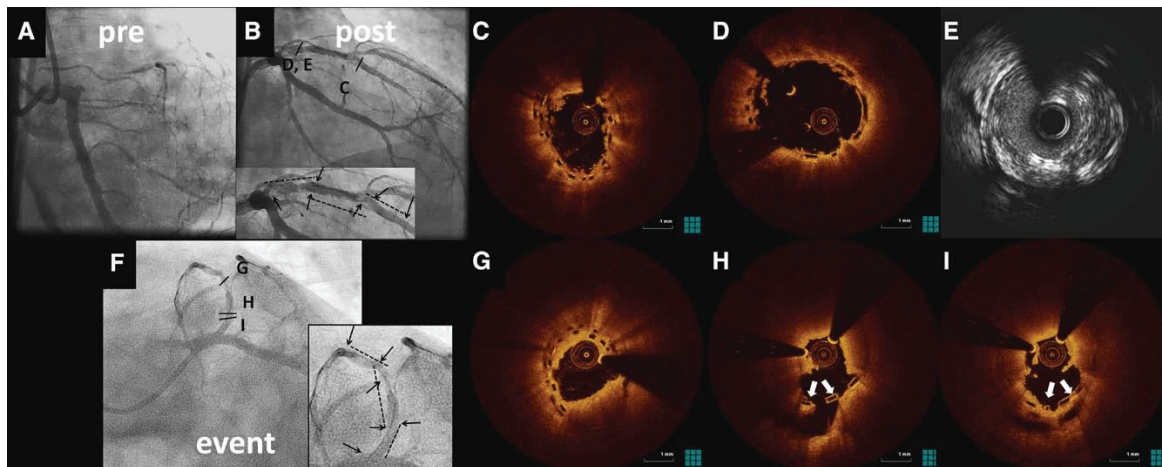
Late bioresorbable vascular scaffold (BVS) thrombosis and malapposition. BVS implantation in a total left anterior descending artery occlusion with postdilatation (A), resulting in acceptable angiographic result with mild haziness (B), but residual thrombus by optical coherence tomography (OCT; C and D) and residual plaque burden by intravascular ultrasound (E). Postdilatation was not repeated, considering the risk of side-branch occlusion. F, Angiogram at event after thrombus aspiration. G through I, OCT shows massive red thrombus, and late malapposition (arrows).
